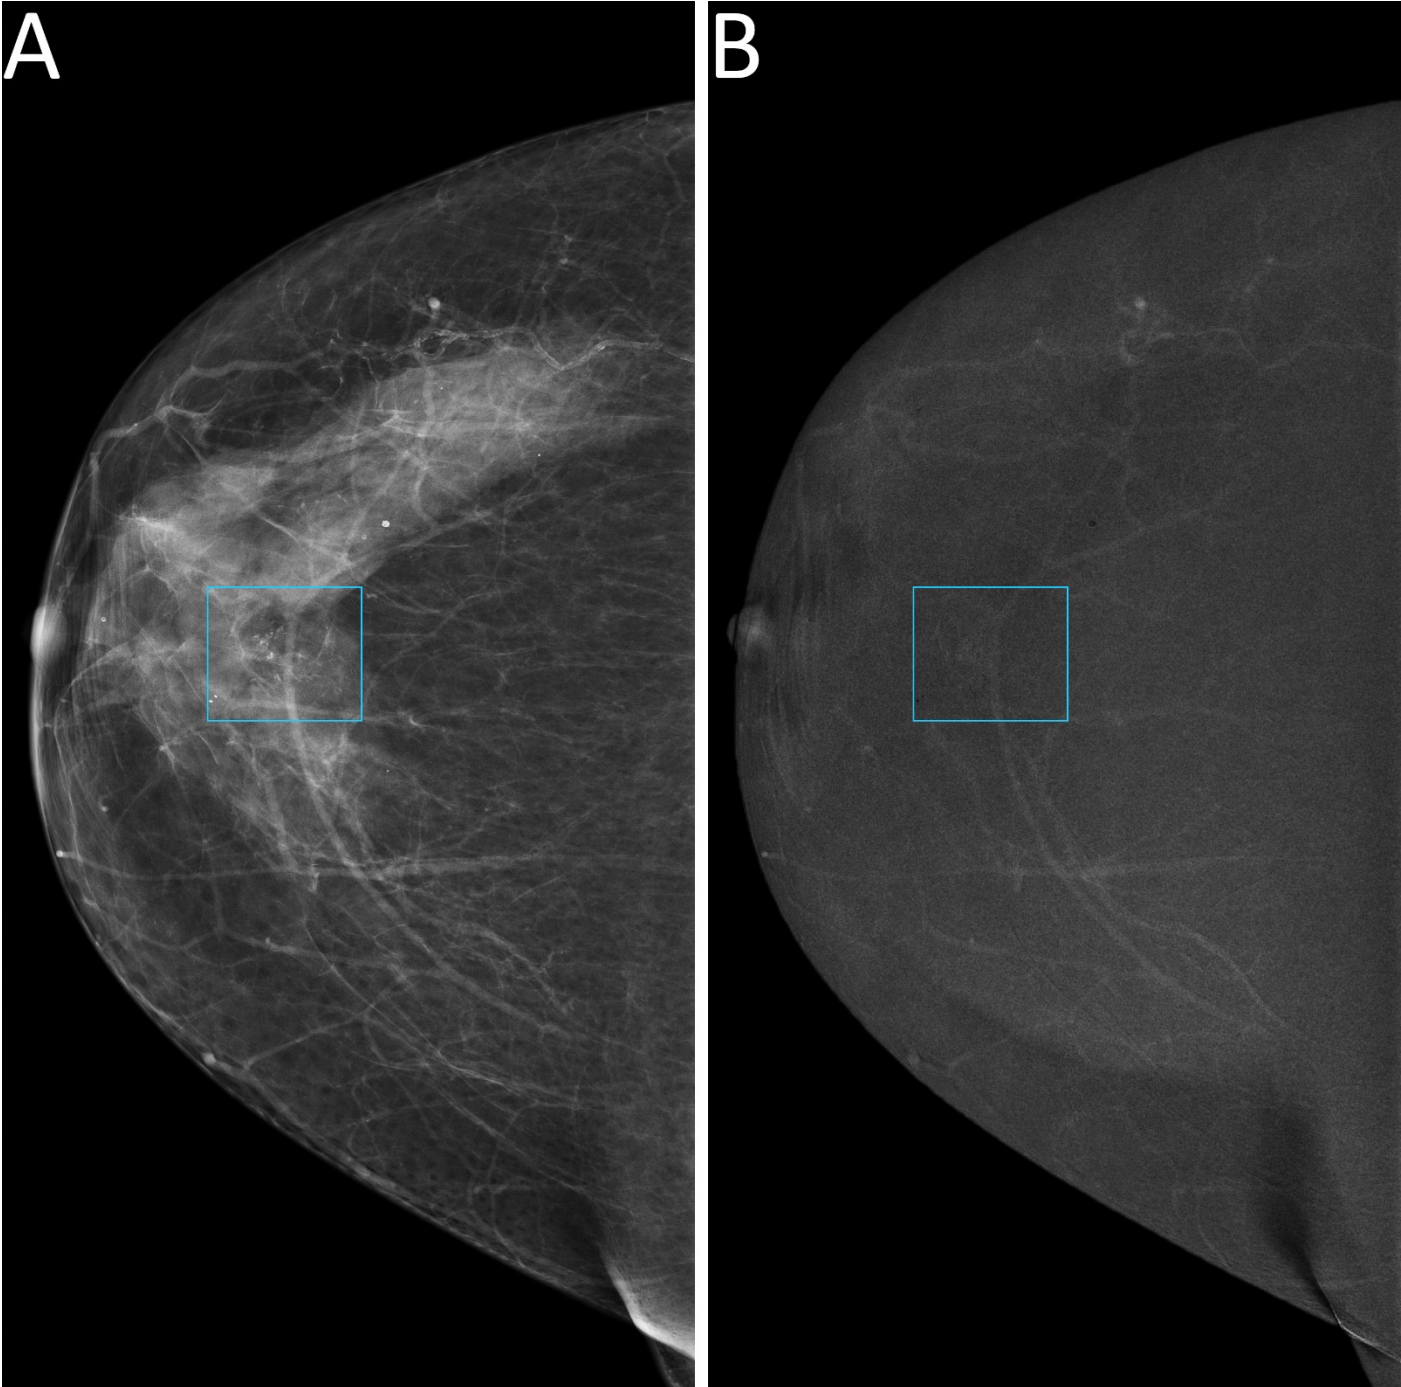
True negative case at CEM. A 49-year-old woman was recalled for a suspicious asymmetry in the upper quadrants of the left breast, not clearly observable on the craniocaudal view (low-energy image, panel A) but definitely noticeable on the mediolateral oblique view (low-energy image, panel C, light blue rectangle). Standard assessment referred this finding to ultrasound-guided core needle biopsy, leading to a diagnosis of fibrosis. Conversely, the absence of enhancement in recombined images, both on the whole craniocaudal view (panel B) and in correspondence of the suspicious area on the mediolateral oblique view (panel D) would have oriented the work-up to a normal result with referral to re-screening
